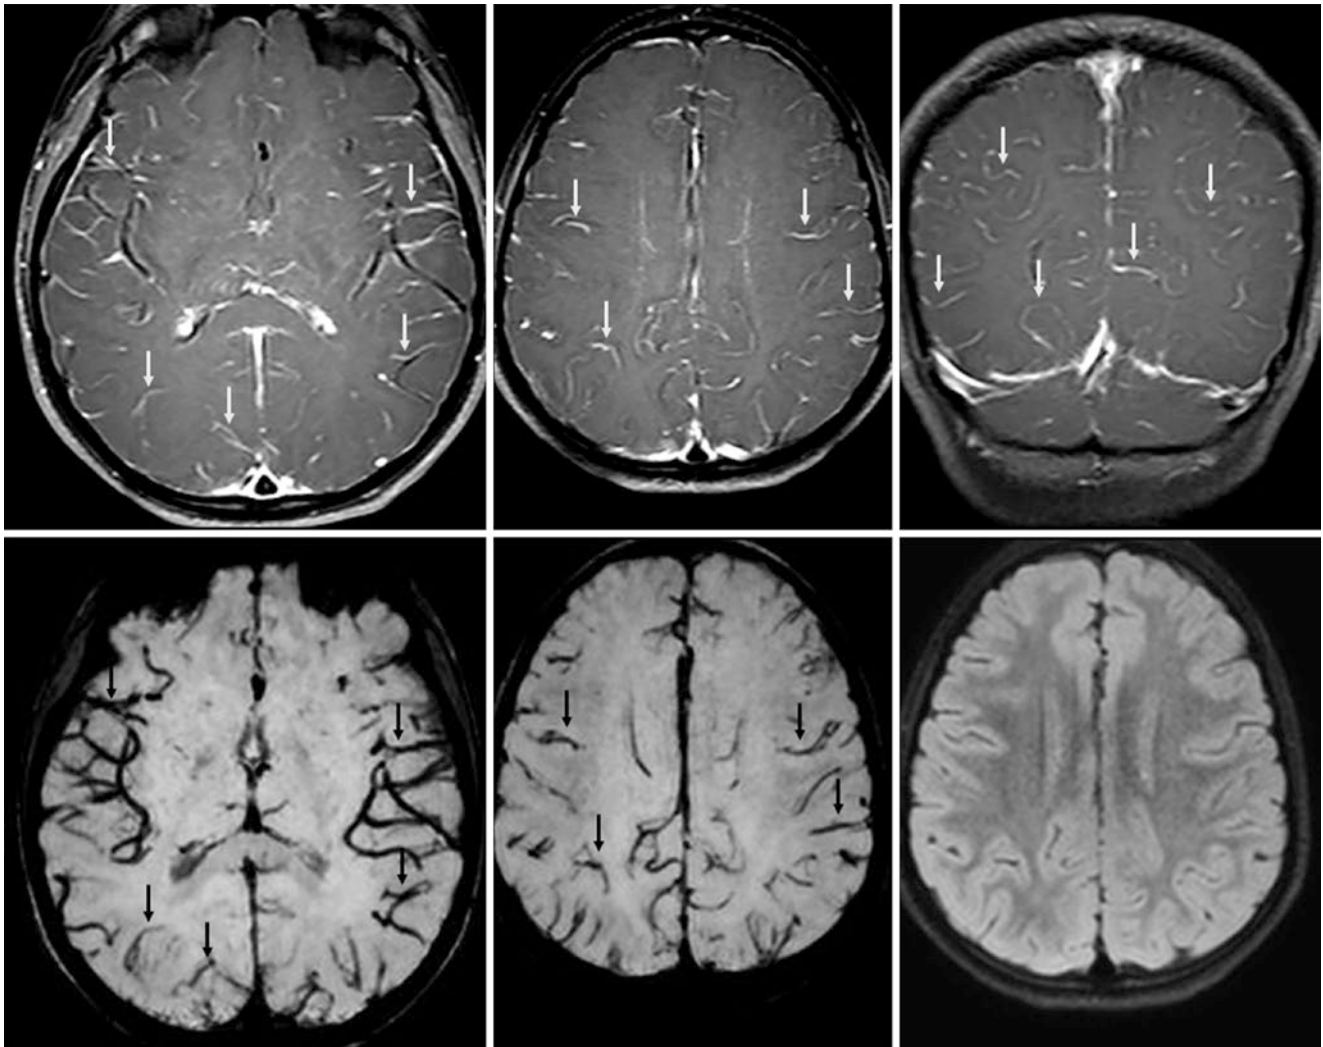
A 5 year old with chronic visual symptoms had a negative 3T MRI under IV sedation that showed moderate pseudo-LMCE (arrows) on axial (top left and middle) and coronal (top right) SET1WIs. On 10 mm-thick sliding MIP SWIs (bottom left and middle), these sites
